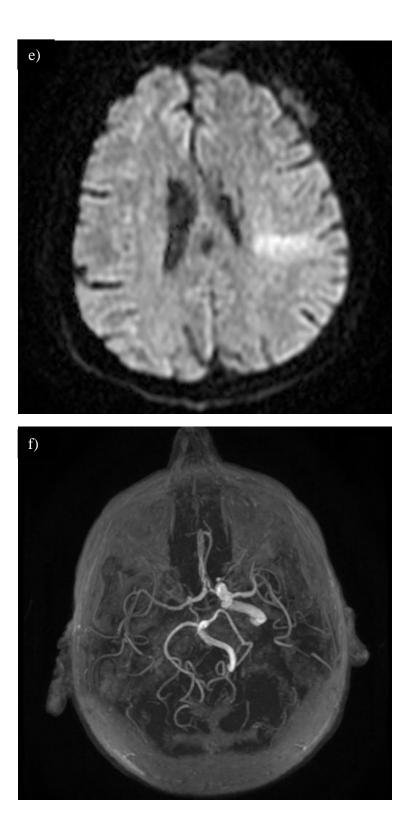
Abbreviations: IH Δ rSO2: interhemispheric rSO₂ difference, MAP: mean arterial pressure, MRI: magnetic resonance imaging, mRS: modified Rankin scale, MTT: mean transit time, T_{max}: time-to-maximum, rSO₂: regional oxygen saturation.
